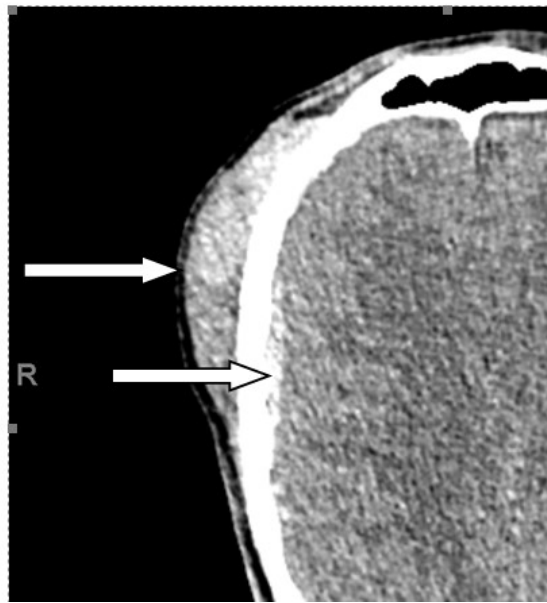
Figure (i) Axial CT on admission demonstrating a large right frontal subgaleal soft tissue swelling with a thin underlying acute subdural haematoma (arrows – note that right and left are transposed on this and all subsequent imaging, as marked). There is a small contrecoup left parietal contusion.
